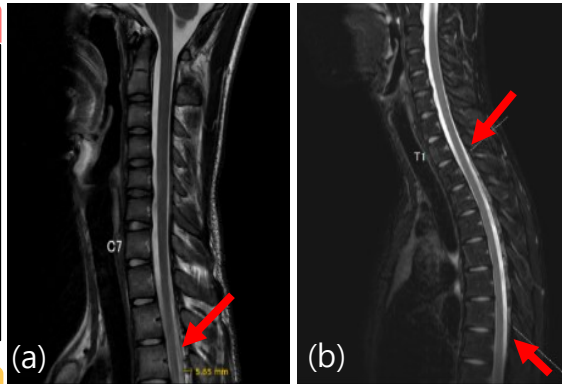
Cervical spinal cord MRI in neck flexed position showed posterior ligamentum flavum was seen along and spinal cord move to forward from T1-2, T7,8 levels. (a) Flexion position on T2-weighted image, (b) Sagittal T2-weighted image shows forward movement of spinal cord from T1-2, T7,8 levels.
